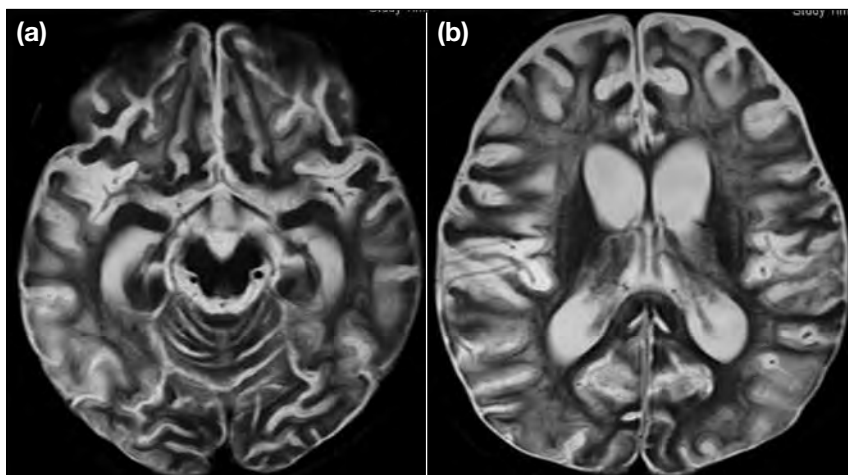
Patient 3. (a, b) Magnetic resonance imaging scans showing progressive atrophy of brain parenchyma with extensive white matter high-intensity T2 signal.
